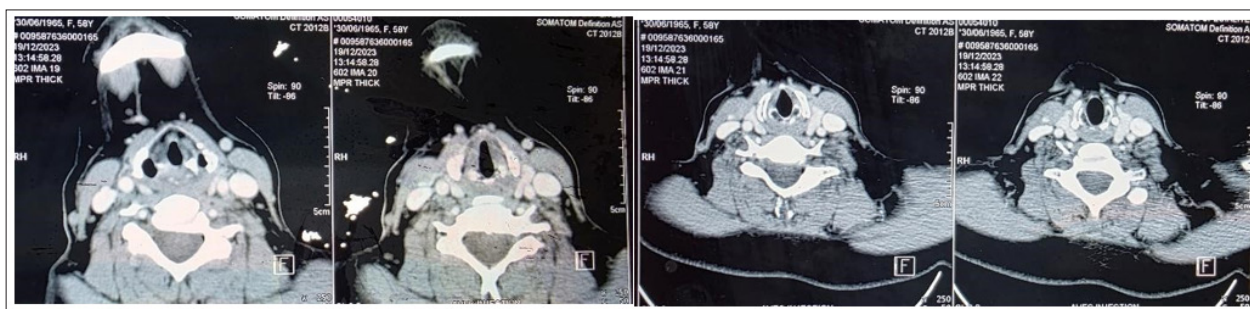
Cervical CT showing a sclerotic appearance of the left arytenoid cartilage without associated lesions.
